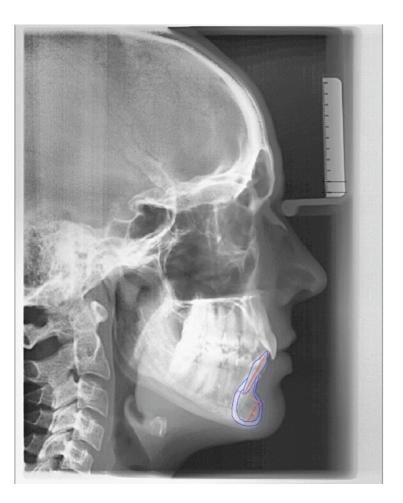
Lateral cephalometric radiography from patient 4
